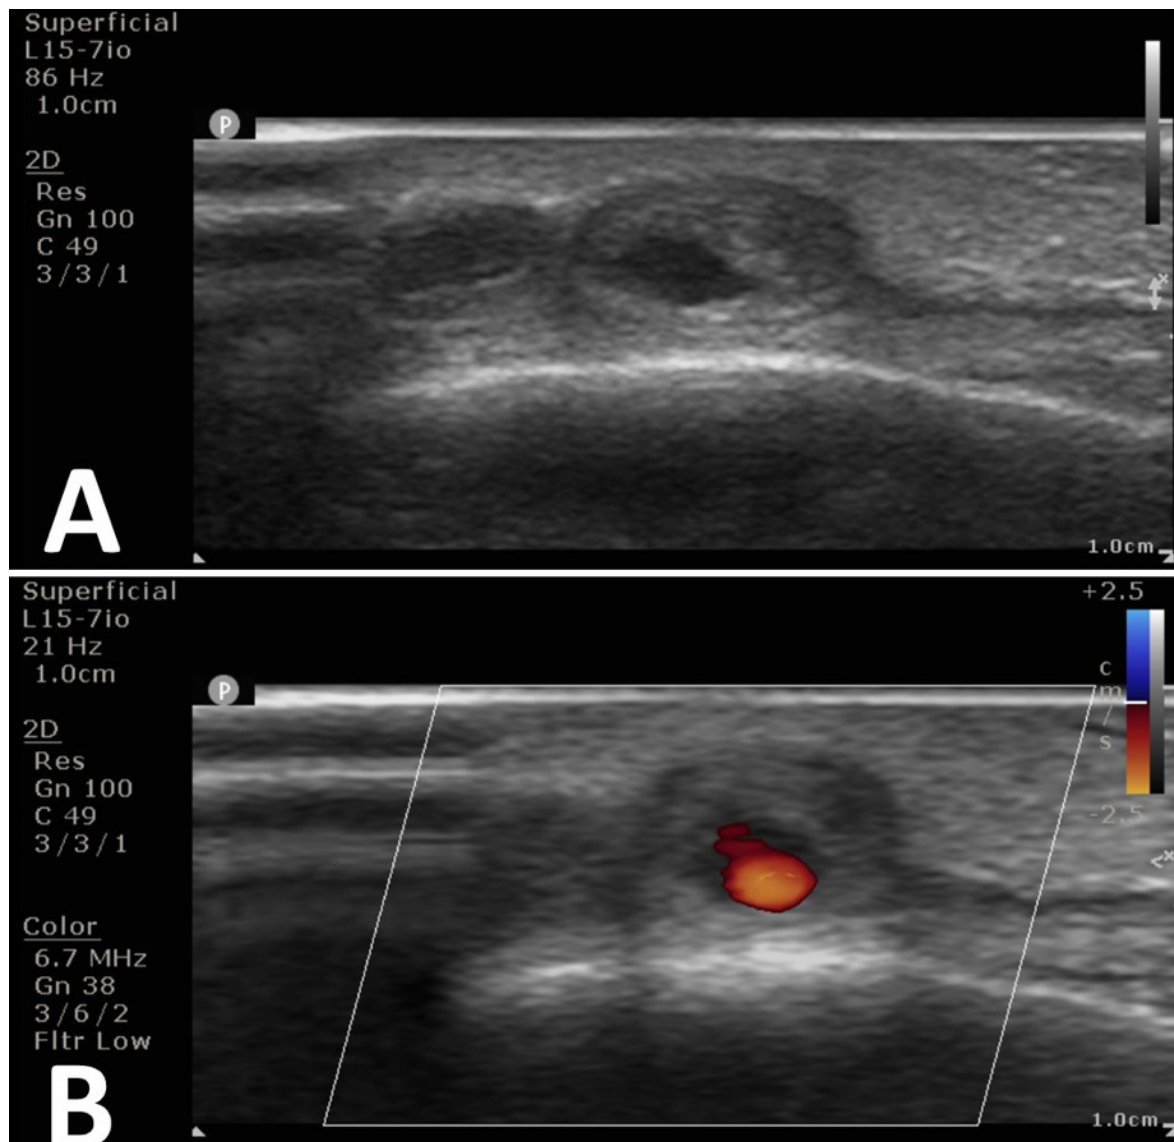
Diagnostic Ultrasound
